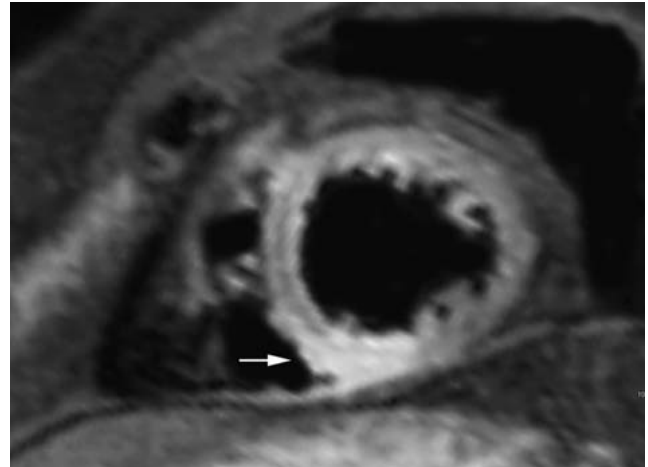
Inferoseptal MI in a 47-year-old man imaged in the acute phase. On T<sub>2</sub>w-STIR MRI, tissue edema is depicted as a homogeneous transmural area of hyper-intense signal located in the inferior and infero-septal left-ventricular wall (arrow)<sup>23</sup>
